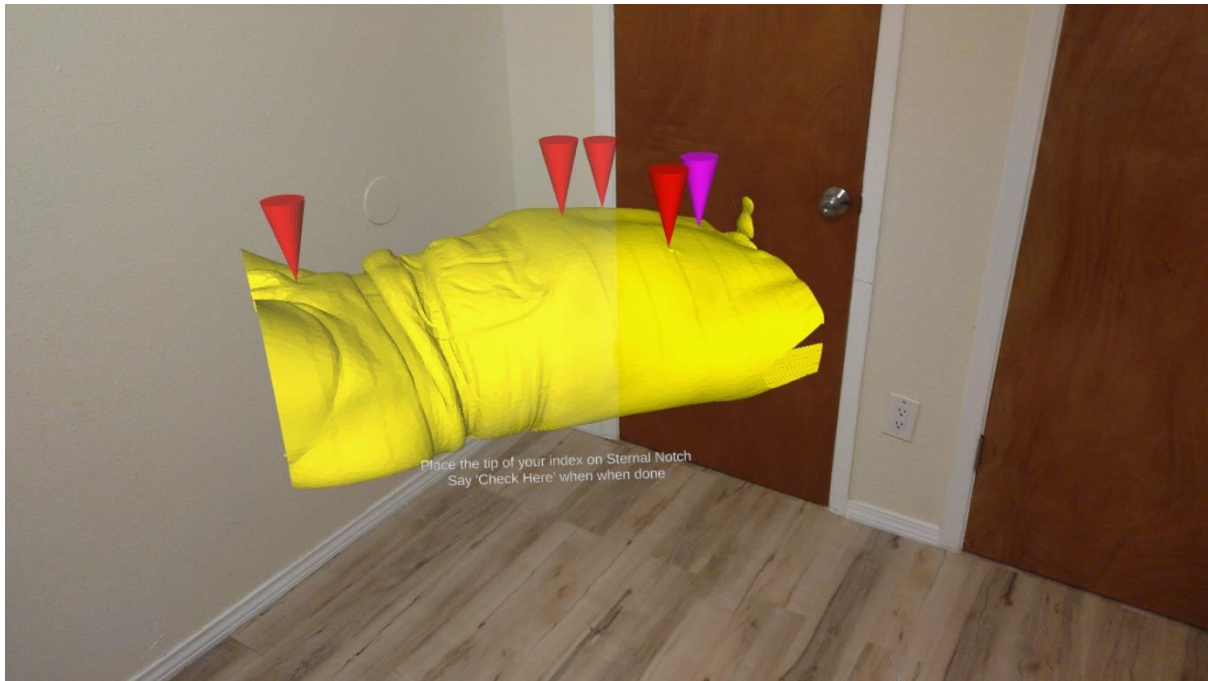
Upon recognition of the “Begin Alignment” command, landmark pins have appeared on top of the subject’s 3D scan model. The yellow region represents the CT scan of the skin. Text feedback containing instructions for the next step is also shown to the user.
